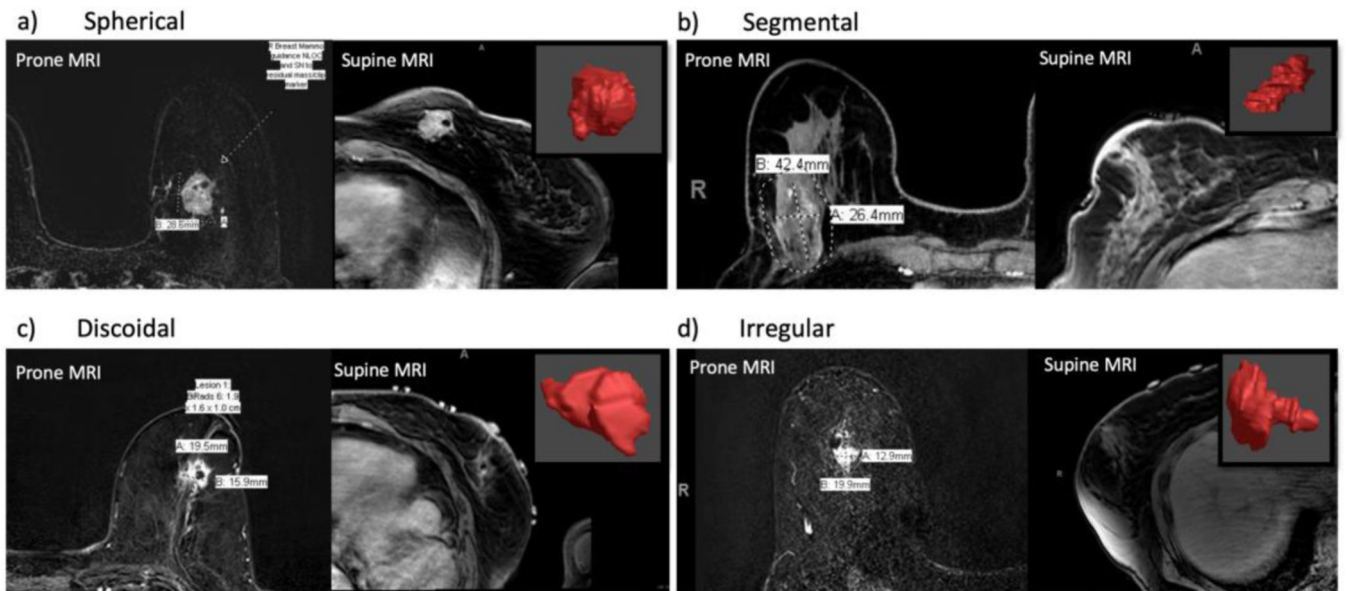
Segmented shape of categorized tumors compared with prone and supine MRI images. For each of the four tumor shapes there is an example of one patient's prone MRI, supine MRI and 3D tumor model (in red)
